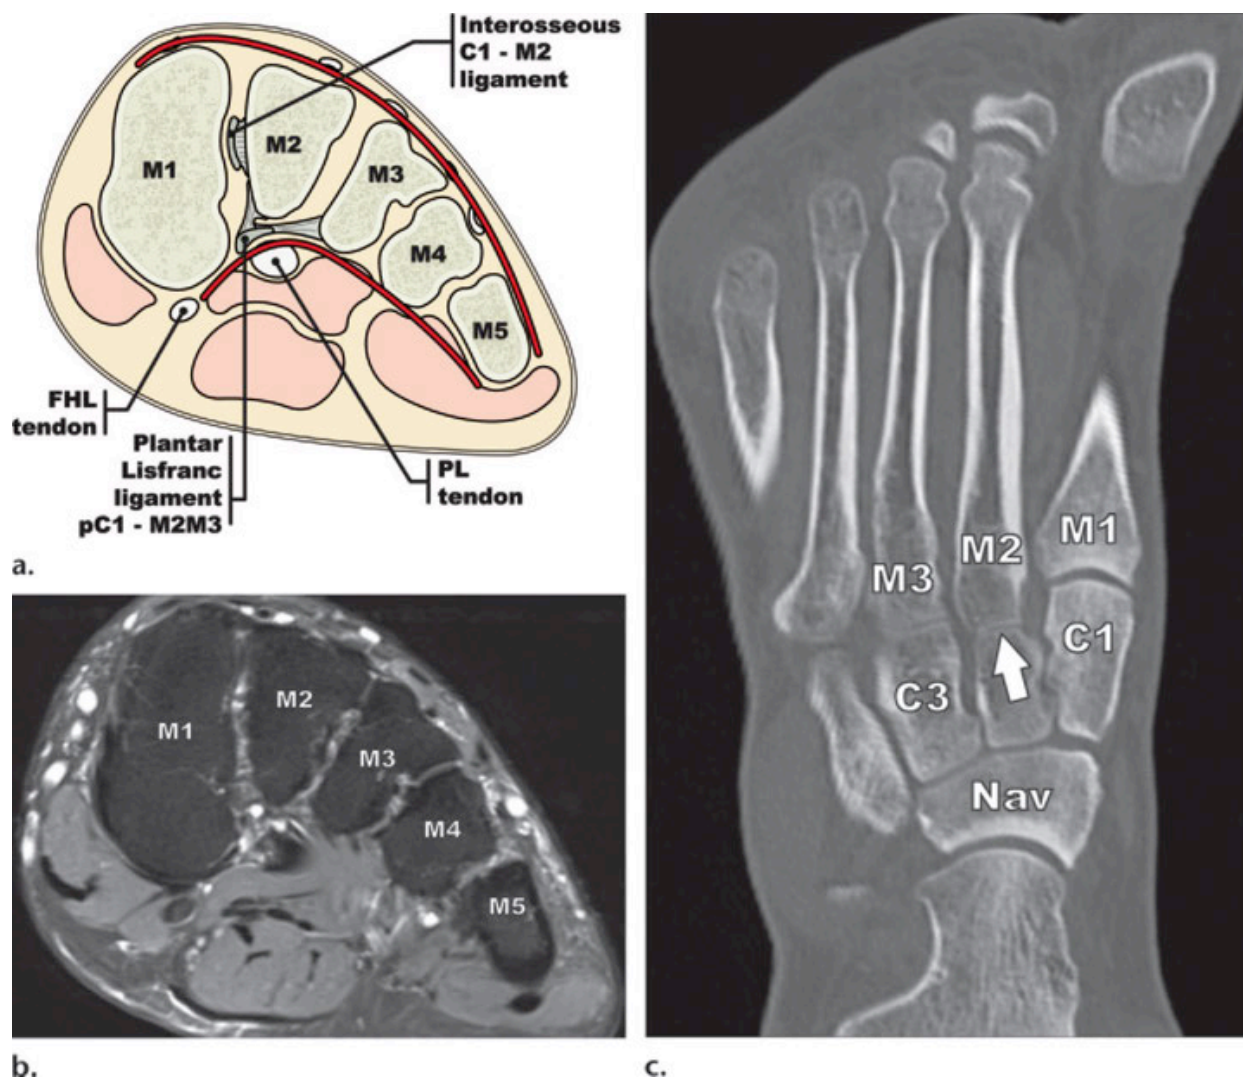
Normal osseous anatomy of the Lisfranc joint complex (a) The normal transverse midfoot arch (curved red lines). The keystone shape of the middle three metatarsal bases helps stabilize the alignment. *M1-5* = metatarsal bases, *PL* = peroneus longus, *FHL* = flexor hallucis longus, *C* = cuneiform, *p* = plantar. (b) Short-axis proton-density-weighted MRI of the left midfoot through the metatarsal bases (*M1*–*M5*) reveals the keystone shape of the middle three metatarsal bases. (c) Long-axis reconstructed CT image of the midfoot shows the mortise-and-tendon arrangement formed by the second metatarsal base (*M2*; arrow) recessed position between the medial and lateral cuneiforms (*C1* and *C3*) that helps preserve joint alignment. *NAV* = navicular.⁵ (Reprinted with permission from *Radiographics*, Siddiqui N, Galizia M, Almusa E, Omar I, Evaluation of the Tarsometatarsal Joint Complex Using Conventional Radiography, CT, and MR Imaging / Musculoskeletal Imaging, 514-531, Copyright (2014))
